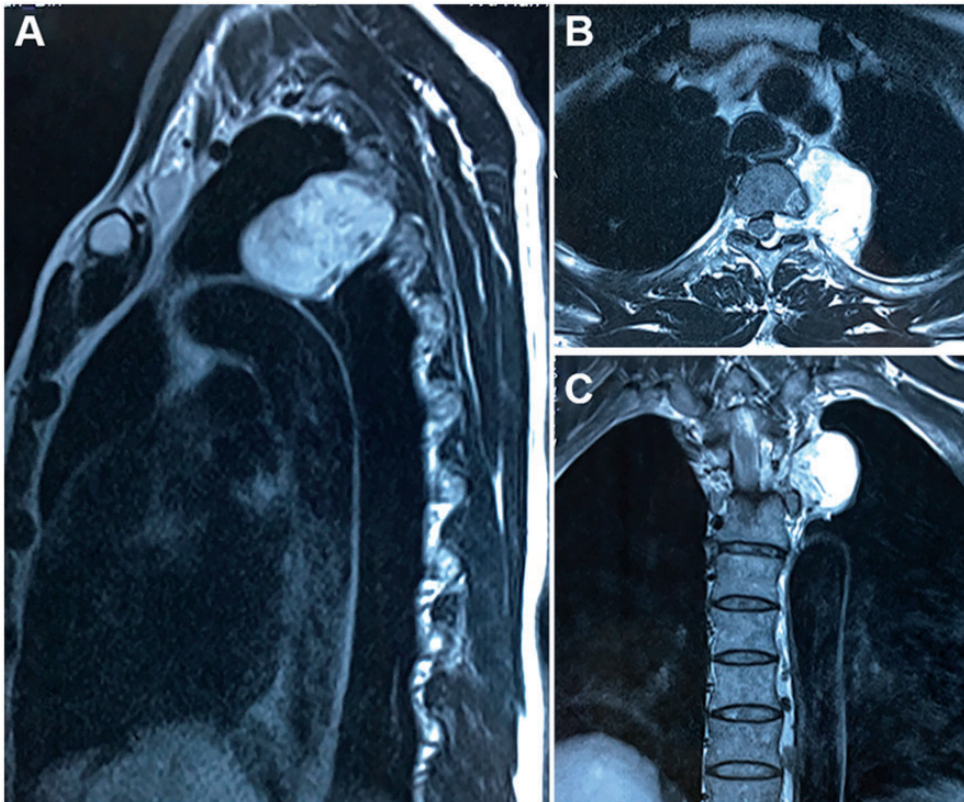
Thoracic magnetic resonance imaging indicated a dumbbell-shaped space-occupying lesion in the (a) sagittal plane, (b) cross-sectional plane, and (c) coronal plane.
